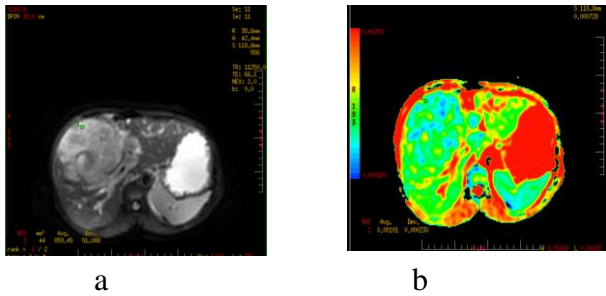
a) The axial DWI image showing metastatic lesion with diffusion restriction, b) ADC of the same with ADC value as : $1.0 \times 10^{-3} \text{ mm}^2/\text{sec}$.
